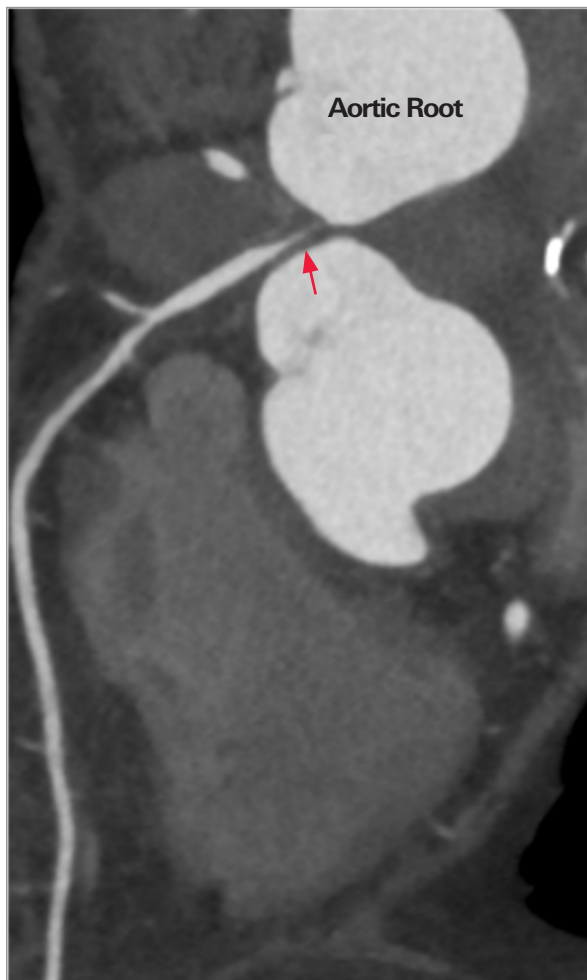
Coronary computed tomography shows narrowing of the origin of the left anterior descending coronary artery caused by tumor invasion (arrow).
